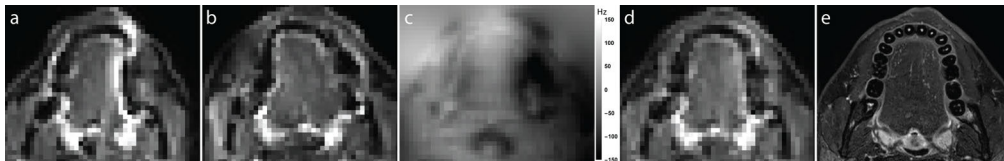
B_0 -inhomogeneity correction using Topup. a: Transverse b_0 -image with phase encoding along the left-right direction. b: Similar b_0 -image with phase encoding opposite to a. Image distortions are present along the phase-encoding direction but opposite to a and b; for example, lateral to the tongue (white arrows). c: B_0 -inhomogeneity map estimated by Topup. Strong inhomogeneities are present at air-tissue interfaces and near teeth lateral to the tongue (white arrow). d: Resulting combined b_0 -image with corrected for B_0 -inhomogeneity. e: T2-weighted Dixon image serving as a high-resolution undistorted gold standard for the distortion correction.
